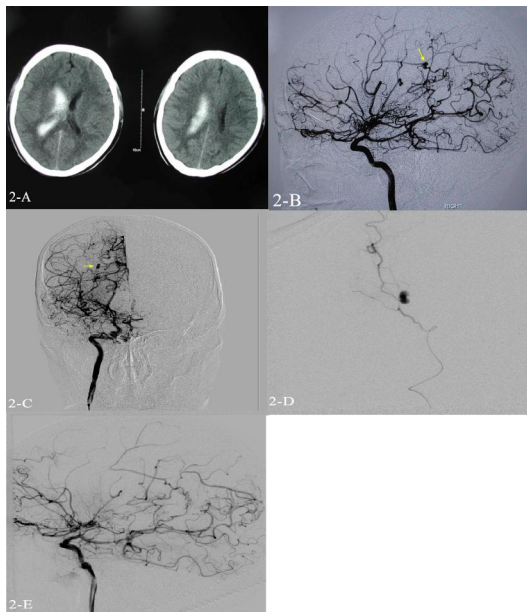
CT scan shows right intraventricular hemorrhage; 2-B, C: Left vertebral angiograms shows a 3-mm aneurysm arising from the distal portion of right lateral posterior choroidal artery (1-B: Lateral view, 1-C: Frontal view); 2-D: Superselective angiogram shows a 3-mm aneurysm, 2-E: Left vertebral angiograms shows complete obliteration of the aneurysm. (Arrow point to aneurysm).
